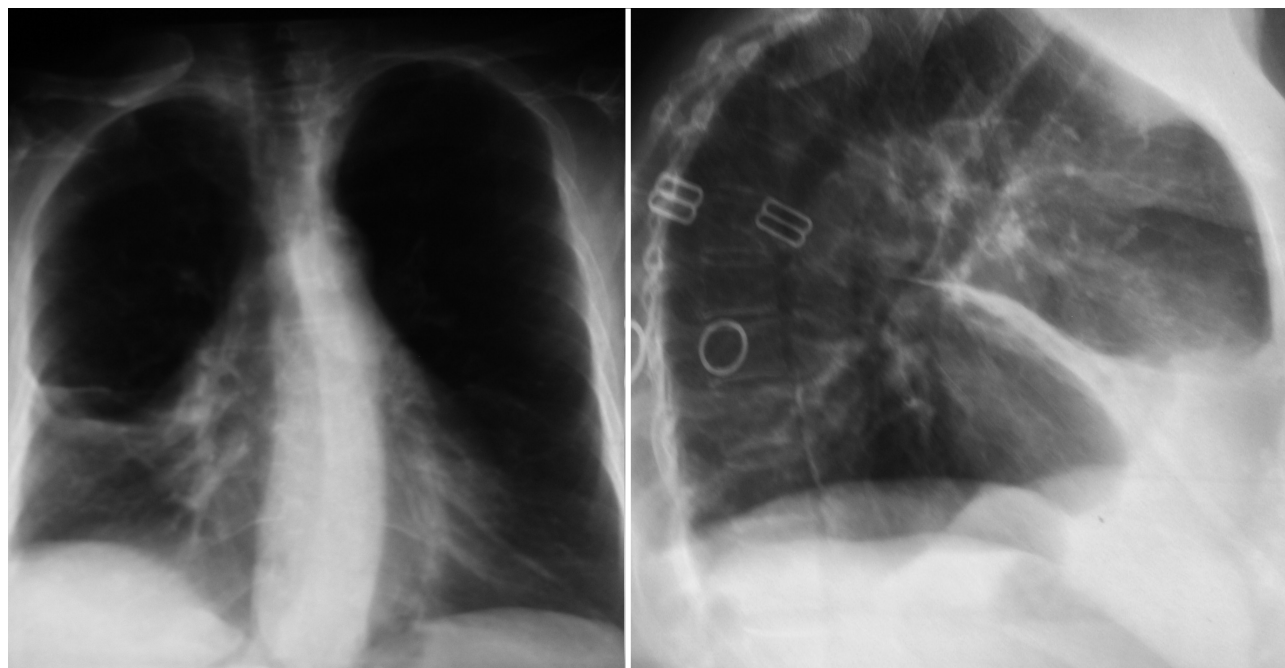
Typical chest X-ray of middle lobe syndrome.
